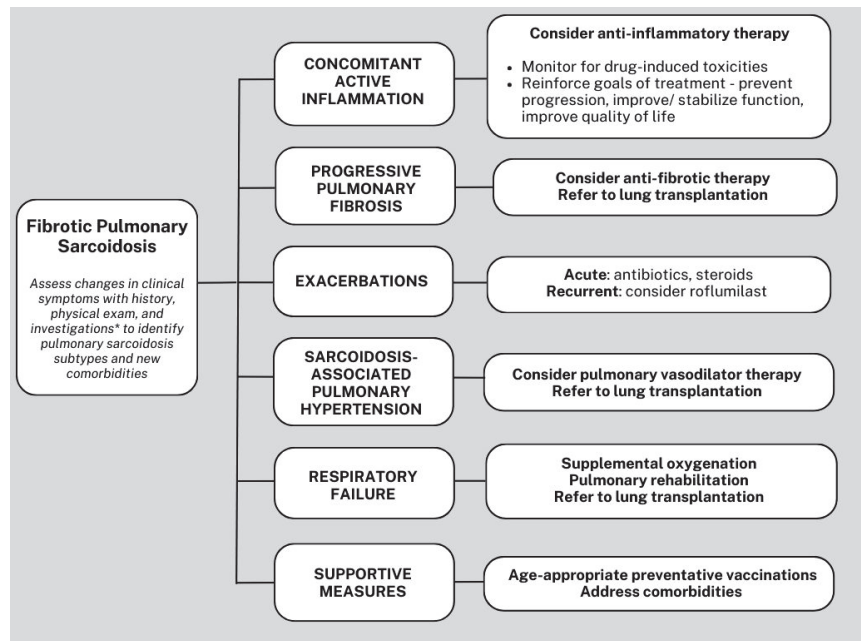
Simplified algorithm for the management of fibrotic pulmonary sarcoidosis. *Investigations with pulmonary function test, 6-min walk test, high-resolution computed tomography, echocardiogram, and fluorodeoxyglucose positron emission tomography integrated with computed tomography.
